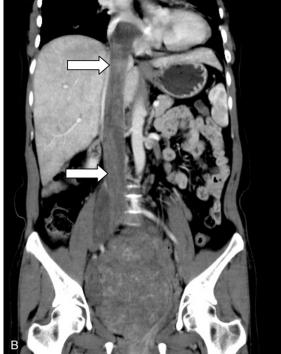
A. Axial CT pulmonary angiography revealed irregular filling defect in right heart cavities. B. Capital CT pulmonary angiography revealed irregular filling defect in right heart cavities.
